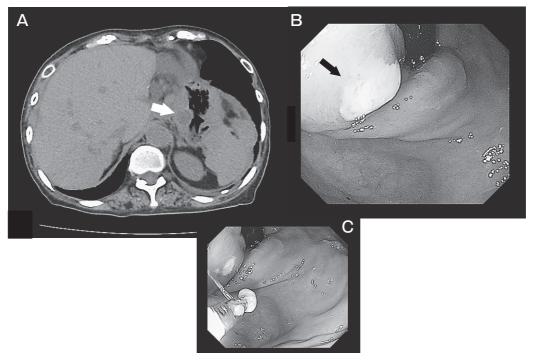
A, Computed tomography of the abdomen showed peri-gastric lymphadenopathy with low CT value (\Rightarrow) ; B, Lymph node abscess ruptured inside the stomach (\Rightarrow) ; C, Pus in the stomach collected using forceps.
